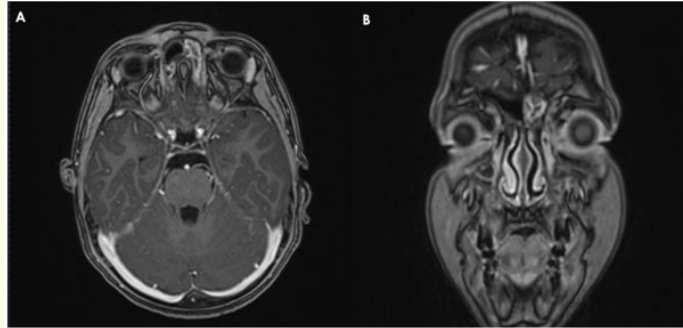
Post-treatment MRI assessment reveals the absence of any persistent tumor lesions in the left orbit.
